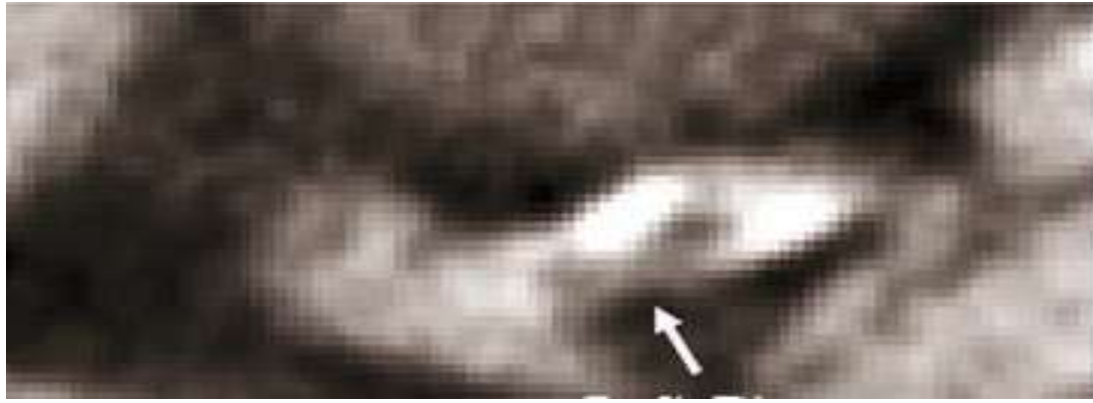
non-contrast study for male patient 54 years old of the left main and proximal left anterior descending. The soft plaque is visible (white arrow) (dark region, representing fat density) with calcified plaque (white regions).)This can theoretically quantitate the volume of soft plaque, fibrous plaque and calcified plaque in any given CT image.
